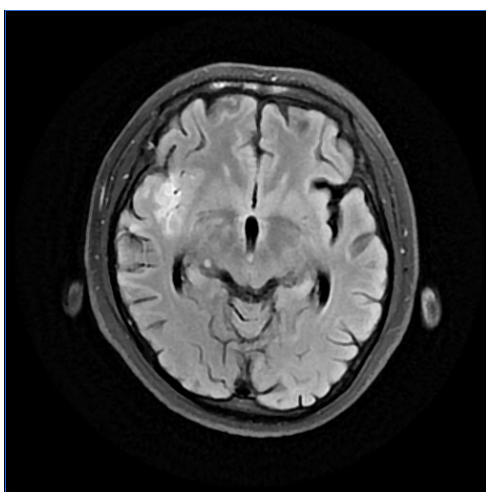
T2-weighted fluid-attenuated inversion recovery (T2-FLAIR) image of patient 02.
